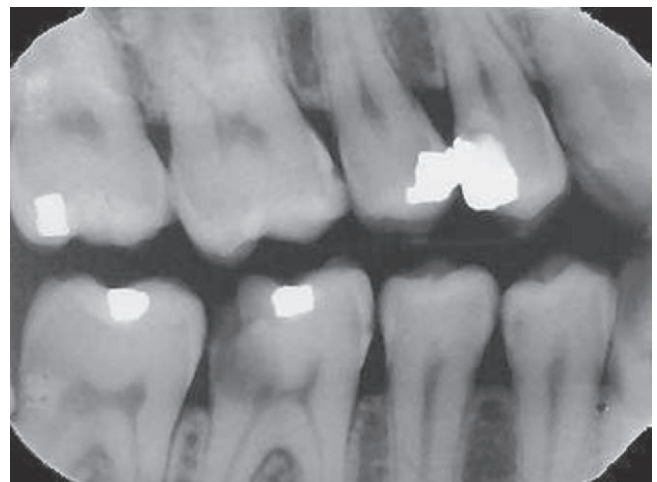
The bite-wing radiograph is a helpful adjunct to establish the relationship of a proximal carious lesion to the bone crest, as with this lower first molar, because it helps to assess the need for a crown lengthening procedure and it helps determine the restorative prognosis for the tooth. (Courtesy Dr. J. Ludlow, Chapel Hill, NC.)
